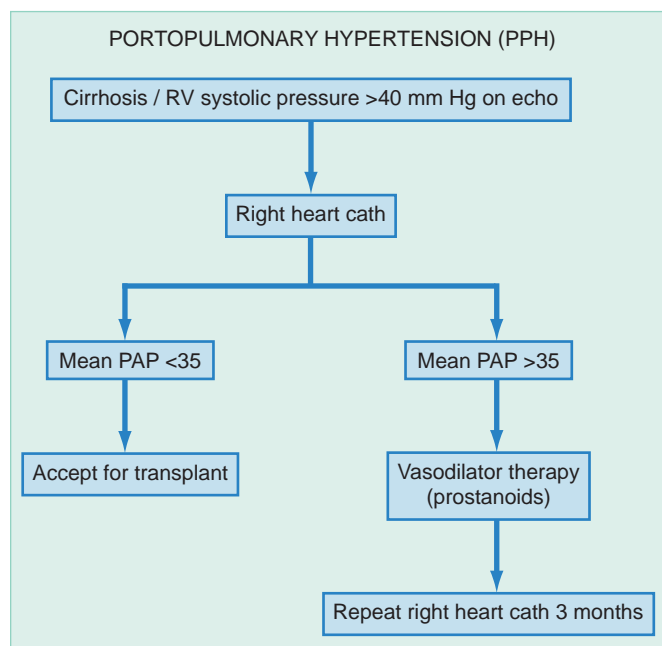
Portopulmonary hypertension: diagnosis and management. Evaluation steps and their management implications are defined. cath, catheterization; echo, echocardiogram; PAP, pulmonary artery pressure (measured in mm Hg); RV, right ventricular.
